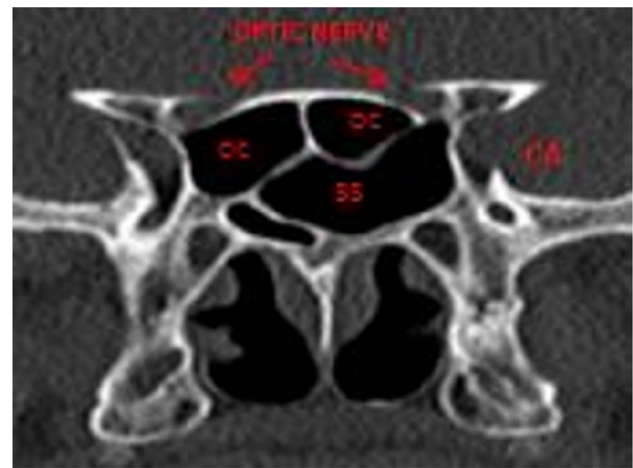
CT scan showing vital structures surrounding the sphenoid ostium such as the optic nerve, internal carotid artery, and the cavernous sinus
